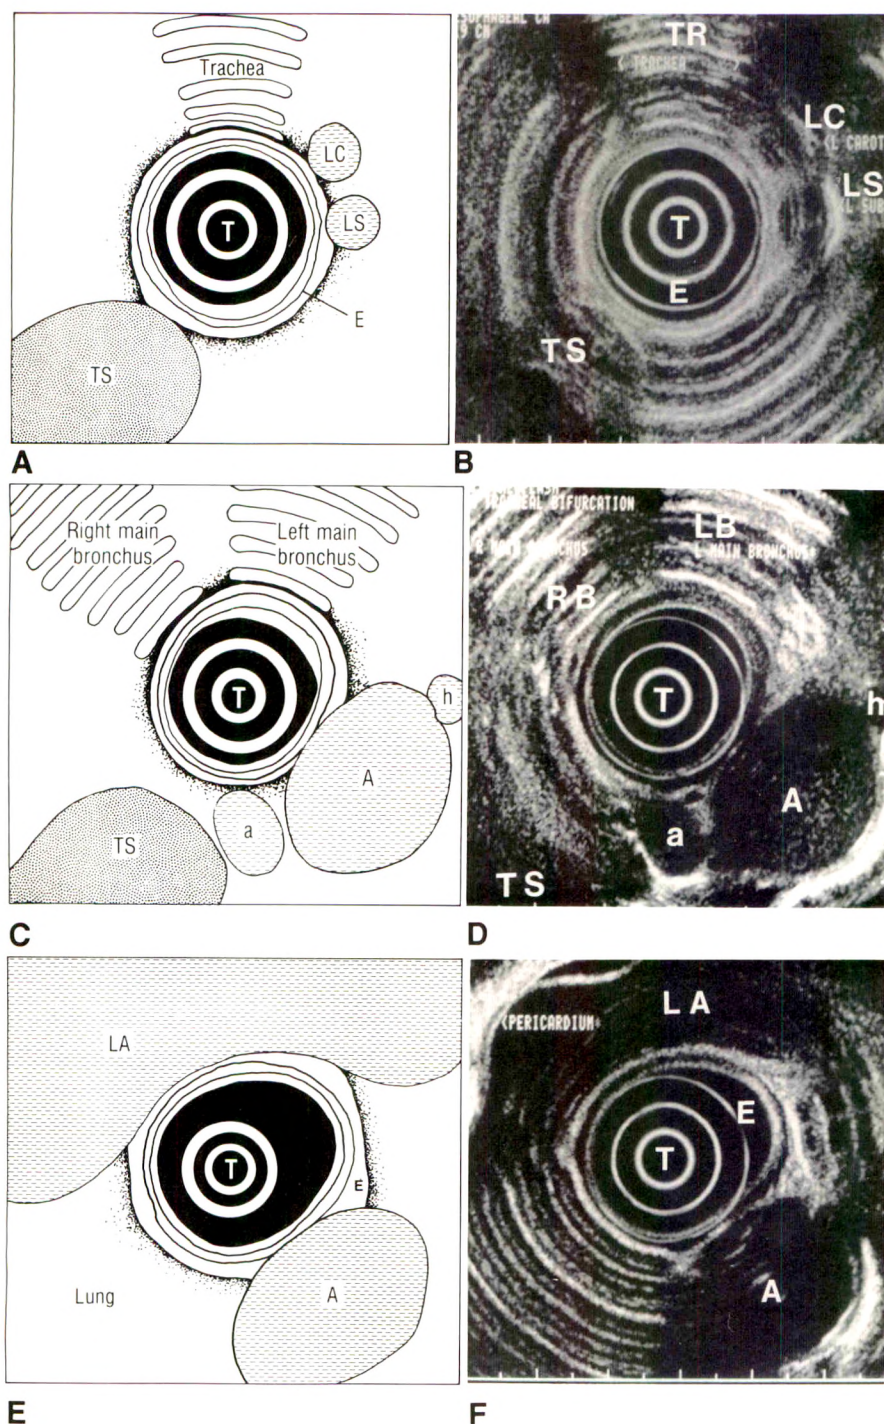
Endoscopic sonography of normal esophagus (E) with 12-MHz transducer (T).
